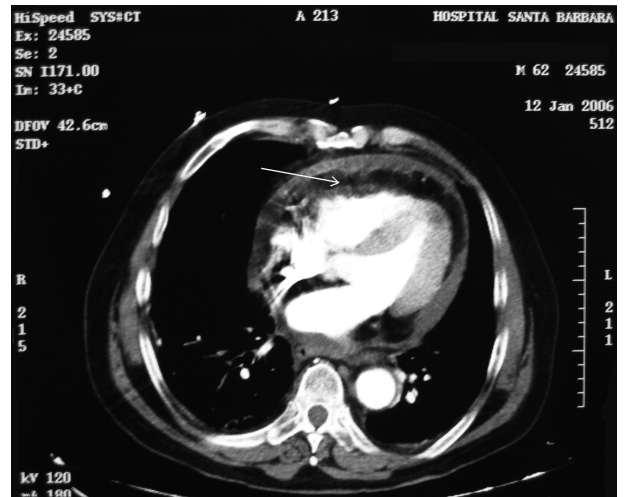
Thoracic CT scan: collapse of right cavities and thick, heterogeneous and septated pericardial effusion (arrow).
